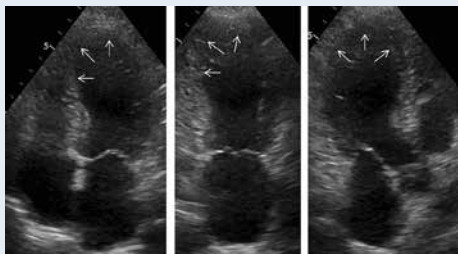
Echocardiography — apical ballooning and hypercontractile basal segments at early stage
